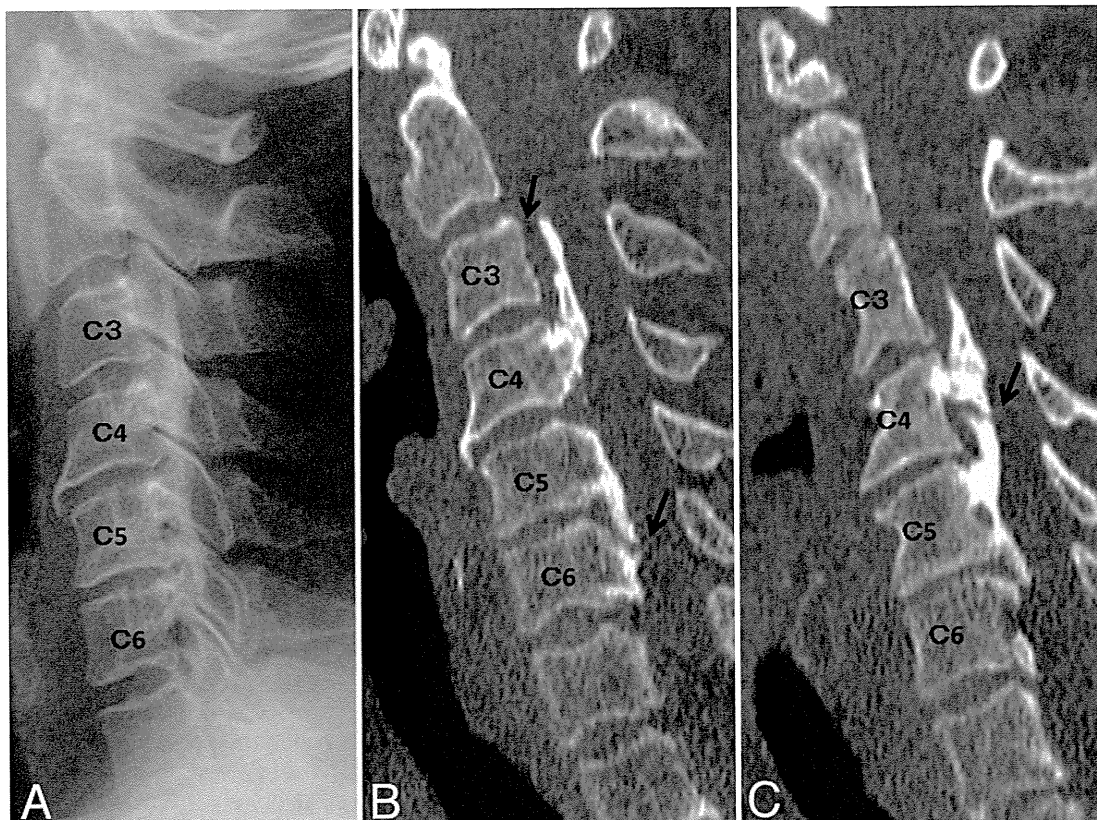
Case 1. Radiograph (A) and CT scans (B and C) of ossifications. The radiograph shows a continuous-type OPLL at the C3–6 level; however, the reconstructed scans reveal the discontinuity (arrows) of ossifications of the nonbridging type.
